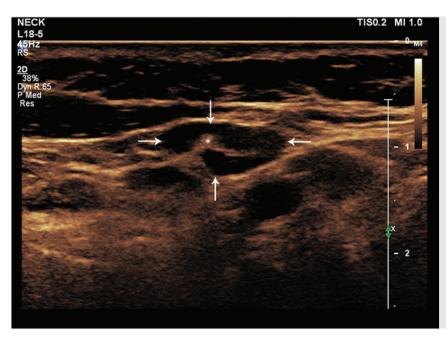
B-mode ultrasound image of the neck showing a less than 1 cm lymph node (*arrows*). The node with an echogenic hilum (*asterisk*), which is one of the characteristics of a benign lymph node, measures around 0.8×0.5 cm.
